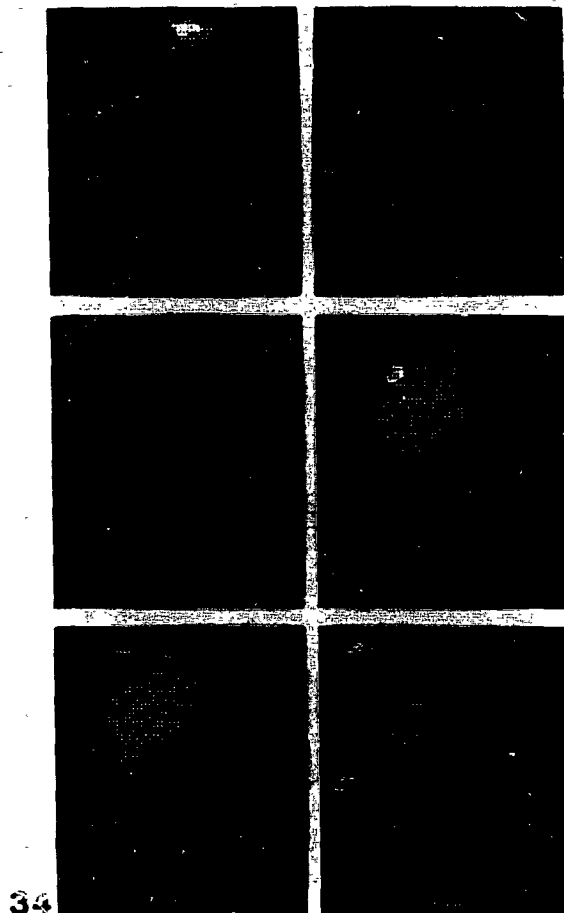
34 Computer display of a serial scintigram of a patient with bile duct obstruction due to islet cell carcinoma of the pancreas.
